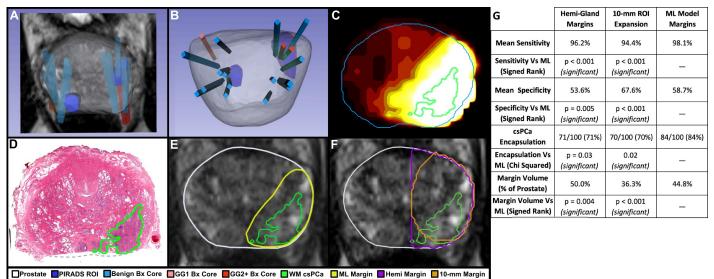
Example case (A-B) input data on T2-MRI and in 3D; (C) CPM, with black->white for low->high csPCa risk; (D) WM Slide defining ground-truth csPCa; (E) ML margin; (F) SOC margins; (G) summary statistics
